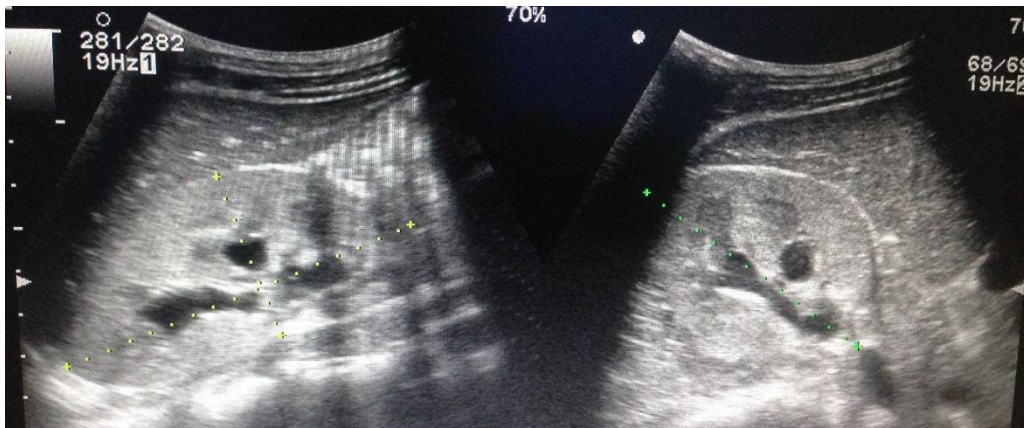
A right renal ultrasound scan of a 10 year old with a 4year history of urine retention, showing echogenic renal cortex, preserved corticomedullary differentiation and mild dilatation of calyceal system.
